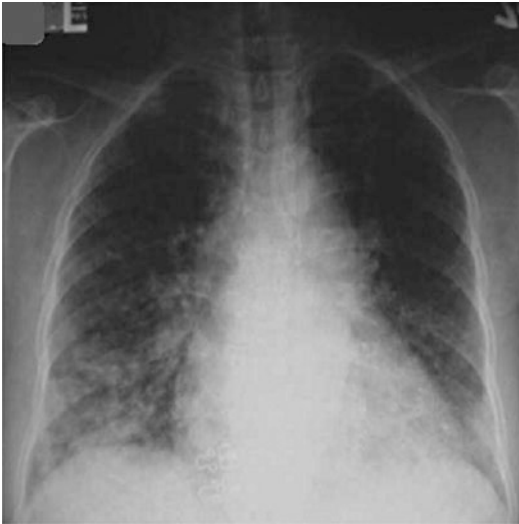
Initial chest x-ray showing bilateral infiltrates in the lower lung zones (From Wu et al. [2]. Reprinted with permission from Elsevier Limited)
